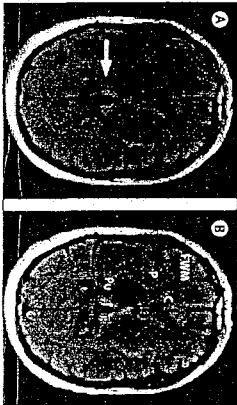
Figure MRI (A) Increased signal intensity in the pulvinar nuclei bilaterally (arrow). (B) Axial signal intensity in the pulvinar (P) is higher than in the head of the caudate nuclei (C). (C) Axial signal intensity in the head of the caudate nuclei (C). (P) and right frontal white matter (PWL).
